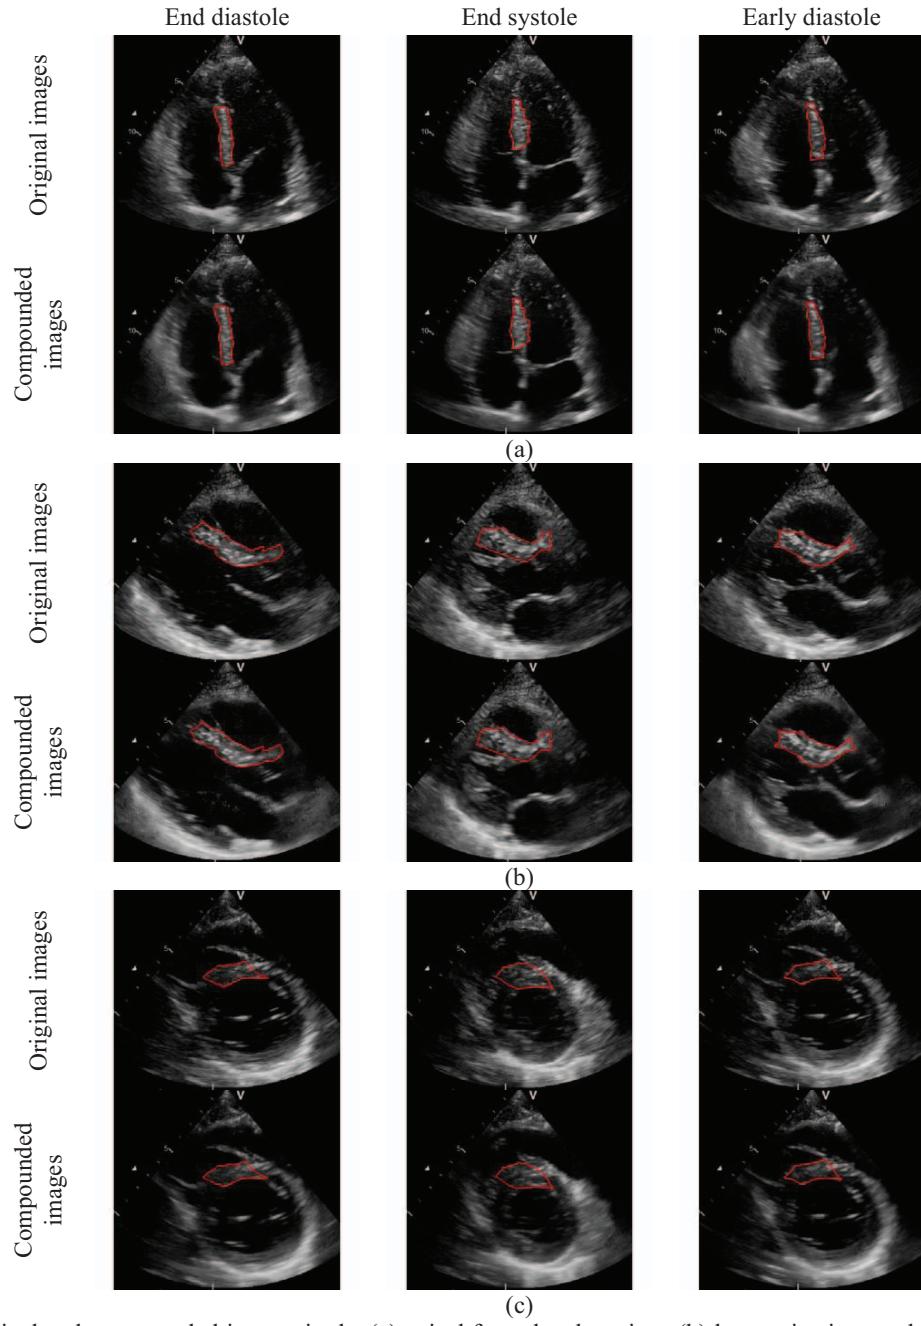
The original and compounded images in the (a) apical four-chamber view, (b) long-axis view, and (c) short-axis view at end diastole, end systole, and early diastole. The septum is traced as indicated by the red curves.
